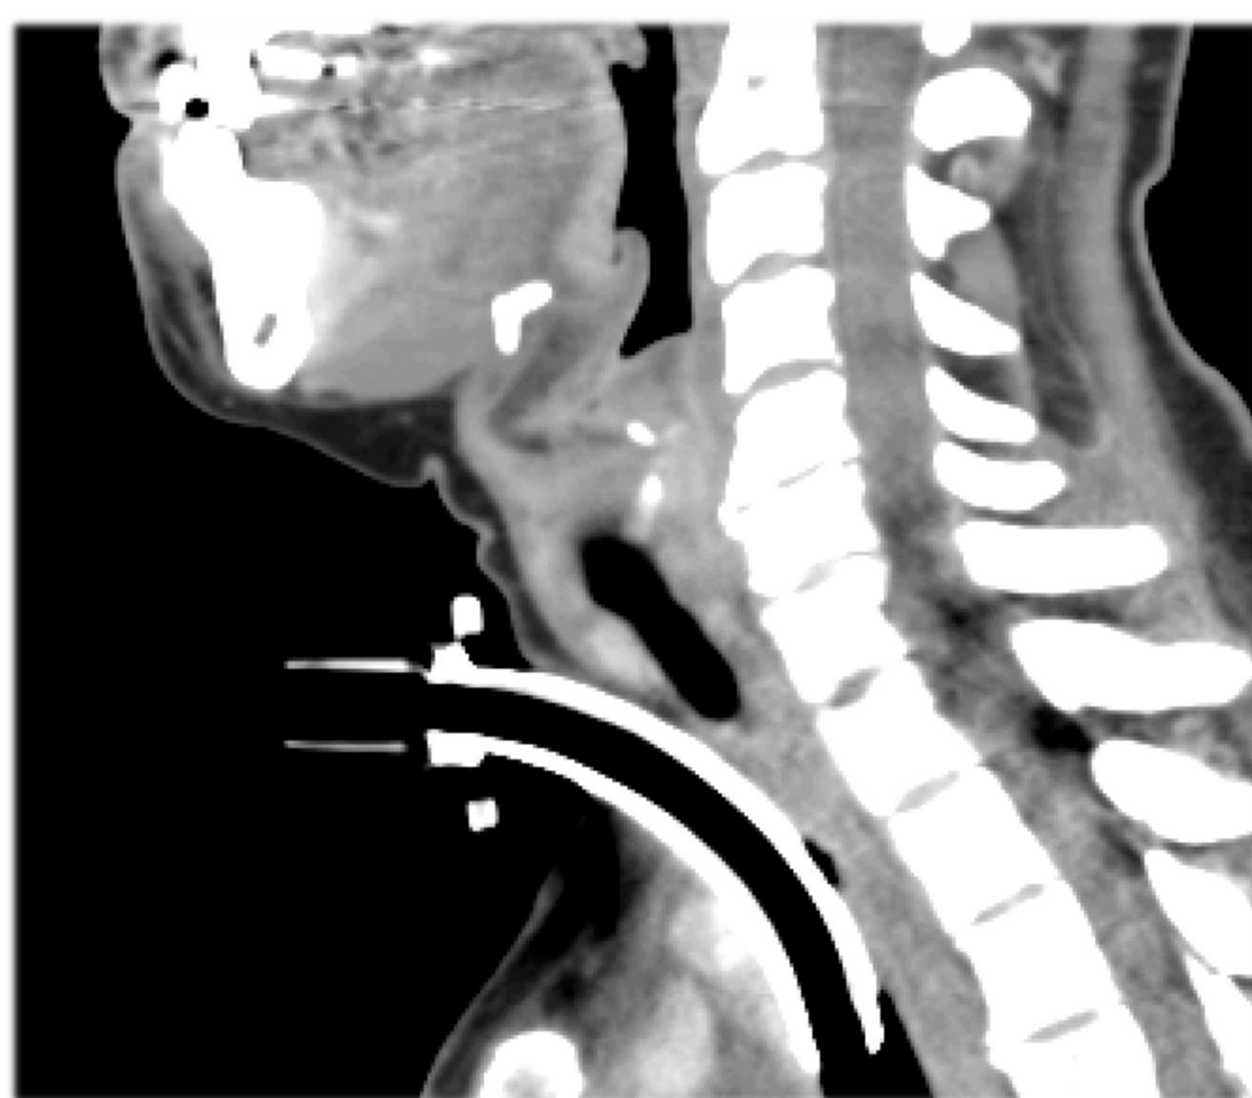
Sagittal CT with 1cm of soft tissue stenosis above the stoma
